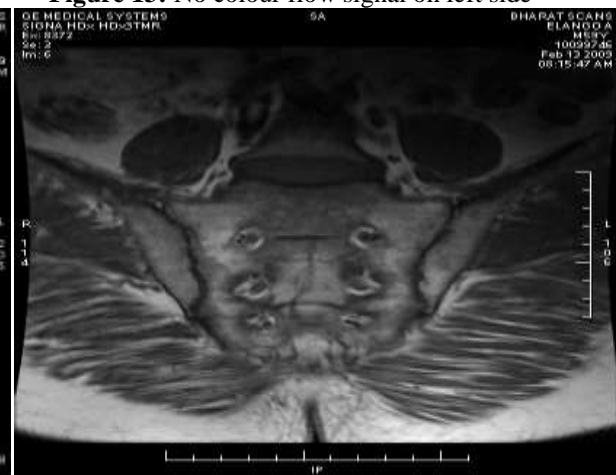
MRI with Bil. sacroiliitis, bone edema, erosions
